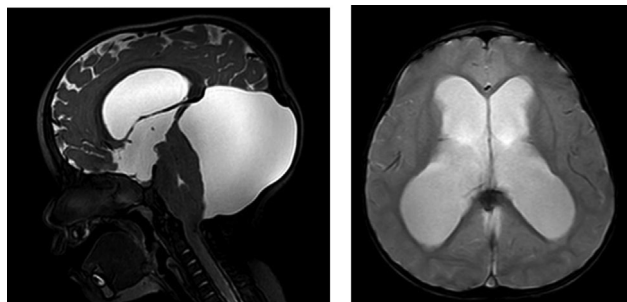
Sagittal and axial magnetic resonance imaging (T2 weighted) showing the retrocerebellar arachnoid cyst (7.6 × 7.3 × 10.5 cm) with hydrocephalus.
